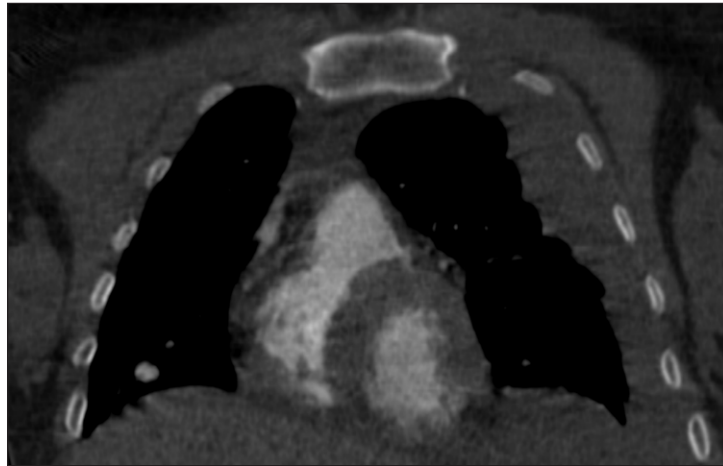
CT image of the hemothorax.
